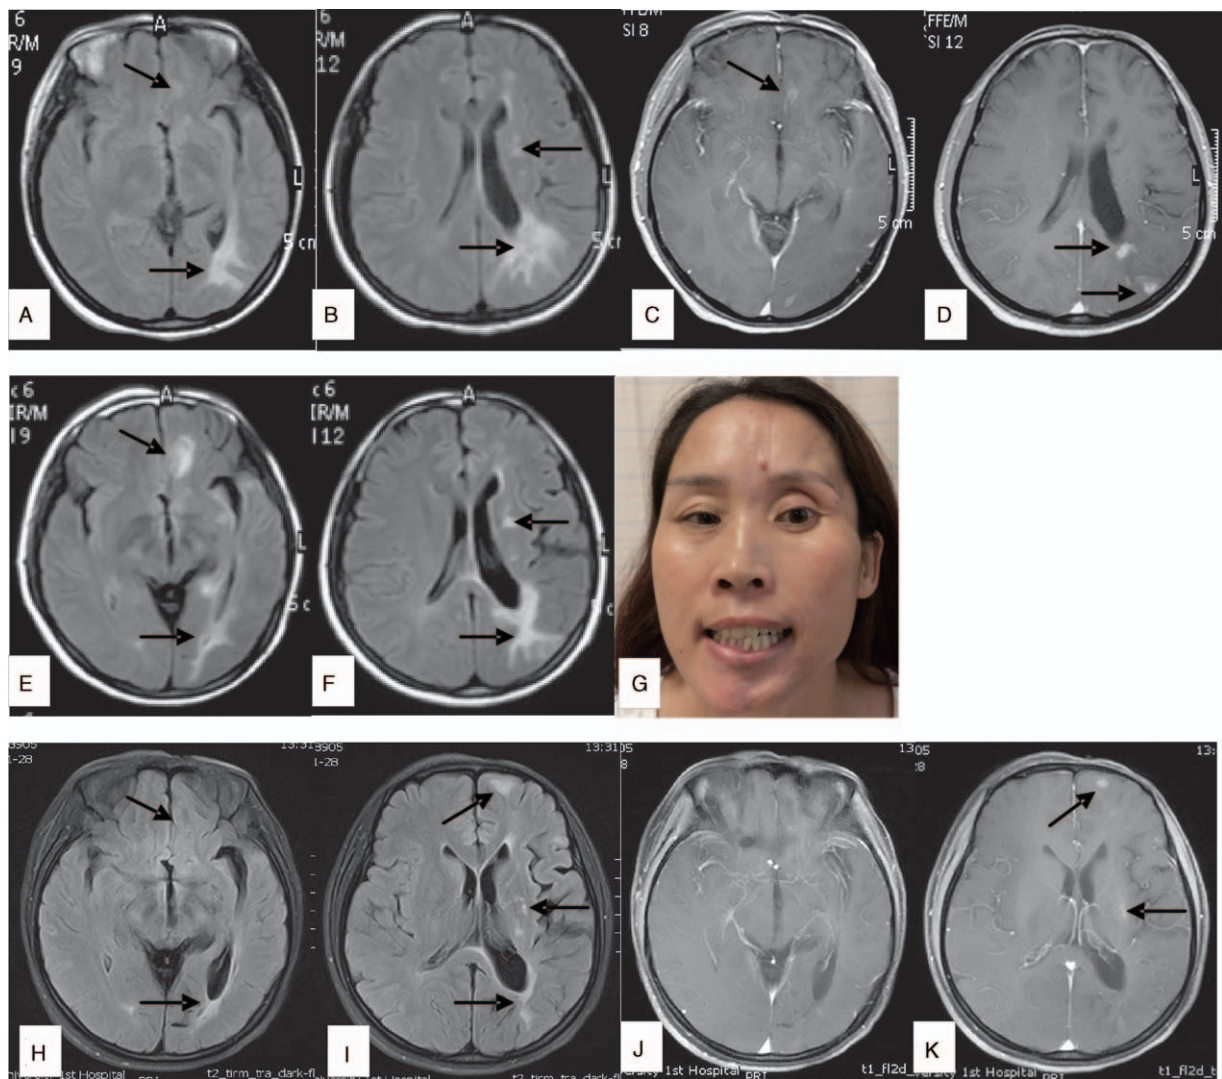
(A–G) MRI axial T2-FLAIR performed in December 2014 showed enlarged left ventricle and multiple hyperintensities in the left frontal, temporal, occipital and parietal lobes and the periventricular area (A and B); some lesions presented heterogeneous enhancement on T1 postcontrast images (C and D). The left ventricle was bigger on MRI axial T2-FLAIR in January 2015; lesions in the left orbitofrontal cortex and the basal ganglia were more widespread, whereas the lesions in the periventricular area were smaller (E and F). In August 2015, the left ventricle enlarged more on MRI, MRI axial T2-FLAIR also showed attenuation of lesions in the left orbitofrontal cortex (H and I) and new lesions in the left superior frontal gyrus (I), some lesions are partially enhanced (J and K). Photograph of the patient (G). FLAIR = fluid-attenuation inversion recovery, MRI = magnetic resonance imaging.
